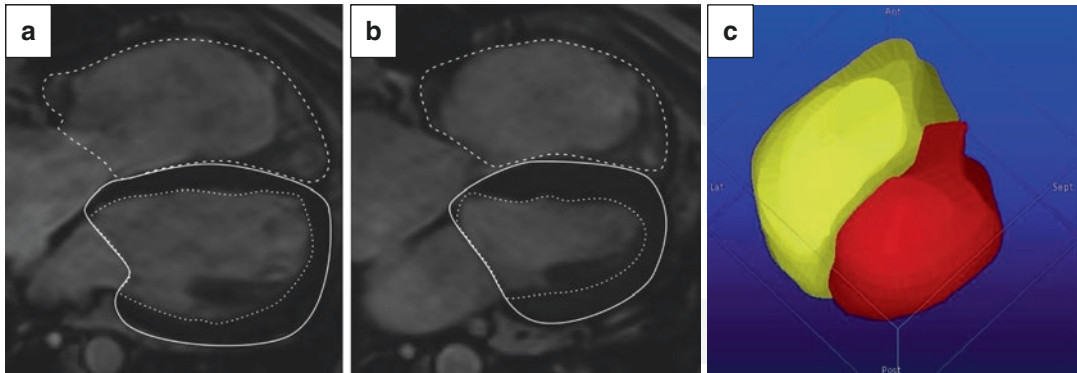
Same patient as in Fig. 10. Volume tracing on MRI cine images. The blood pool area of the left ventricle (fine dotted line) and right ventricle (dotted line) are traced in end-diastolic (a) and end-systolic (b) phase. From this the ventricular volume and function can be calculated (volume rendering of both ventricles shown in c). End-diastolic volumes for left and right ventricles are 156 mL and 358 mL, respectively. End-systolic volumes
